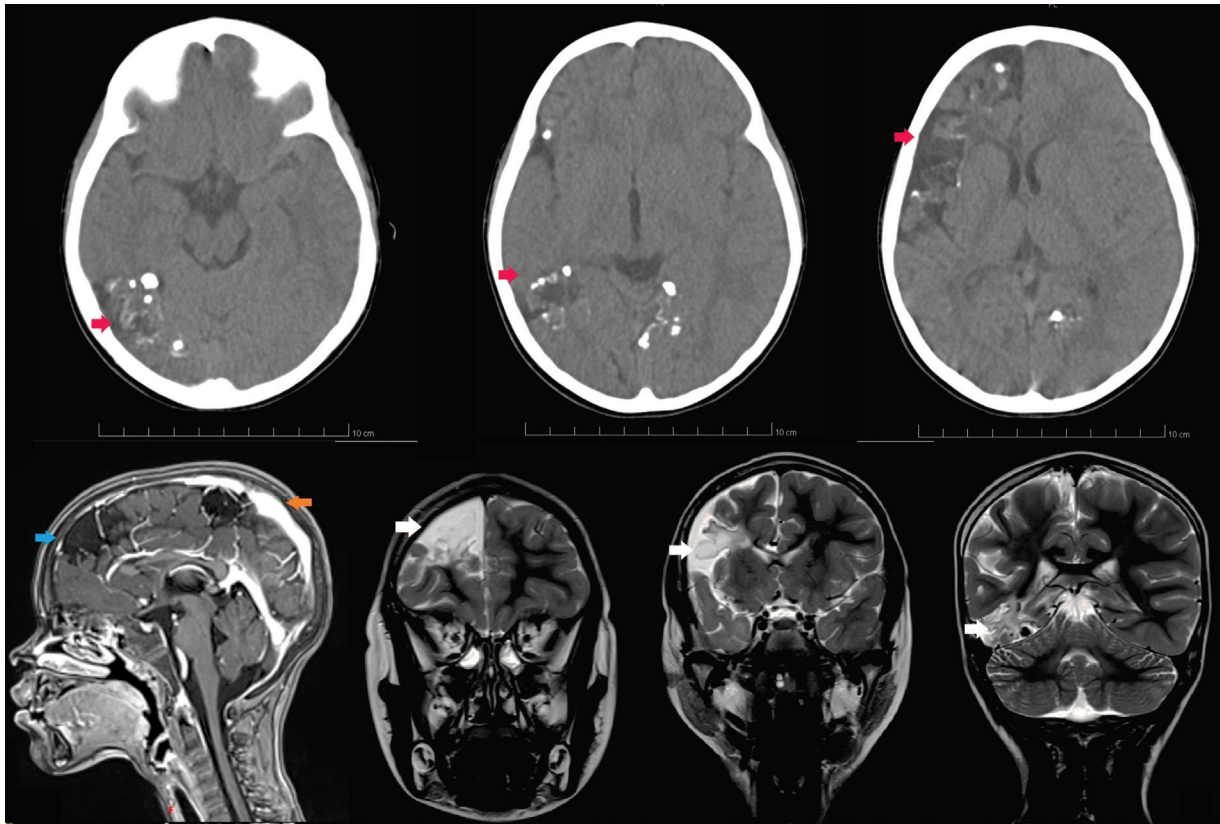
Top line: head CT sequence in axial cuts, showing multiple subcortical and irregular calcifications dispersed in the right brain hemisphere and the calcarine gyrus, along with the tram-track sign (red arrow). Bottom line: head magnetic resonance (MRI), contrast enhancing images showing leptomeningeal malformations with brain parenchymal loss (blue arrow), and leptomeningeal thickening (orange arrow). Head MRI, T2 sequence in coronal cuts, showing leptomeningeal capillary malformations (white arrows) along the right hemisphere.
